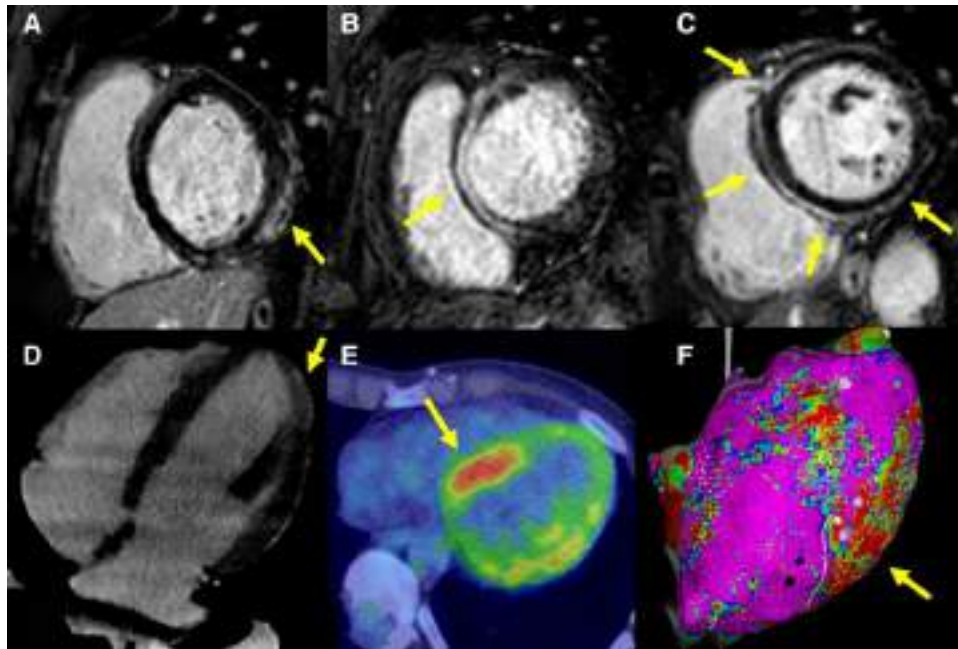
Imaging findings in arrhythmic myocarditis. Imaging findings are shown for patients with arrhythmic myocarditis. (A–C). CMR showing nonischaemic LGE in a patient with: (A) autoimmune myocarditis (inferolateral distribution, arrow); (B) *FLNC* gene variant (septal distribution, arrow); (C) *DSP* gene variant (ring-like distribution, arrows). (D) CT scan showing nonischaemic late iodine enhancement (lateral apical distribution, arrow) in a patient with acute myocarditis and normal coronary arteries. (E) FDG-PET scan consistent with hot-phase cardiomyopathy in a patient with *LMNA* gene variant (septal distribution, arrow). (F) Endocardial bipolar EAVM (left anterior oblique view; cut-off values 0.5 mV for dense scar—red; 1.5 mV for normal voltage—purple) showing low-voltage areas (dominant inferolateral distribution, arrow) in a patient with chronic myocarditis (cold phase). CMR, cardiac magnetic resonance; *DSP*, desmoplakin gene; EAVM, electroanatomic voltage mapping; FDG-PET, 18F-fluorodeoxyglucose positron emission tomography; *FLNC*, filamin C gene; LGE, late gadolinium enhancement; *LMNA*, lamin A/C gene.
